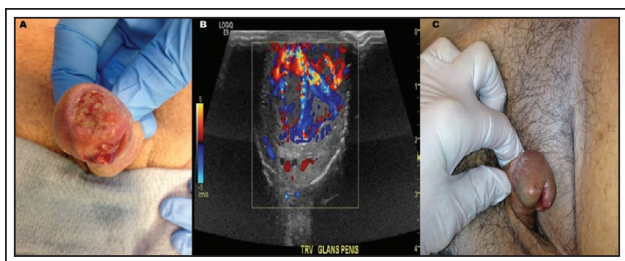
Penile mass. A) Physical examination: small inflammatory lesion coming from the ventral aspect of the meatus with an associated non-tender, distal 3 cm penile glans mass deep to the surface epithelium with an overlying ulcer from the prior biopsy. B) Penile ultrasound showing a 2.4 cm x 2 cm x 2.3 cm vascular mass in the glans penis. C) At 6 weeks postoperatively the patient had a well healed cosmetic result.
